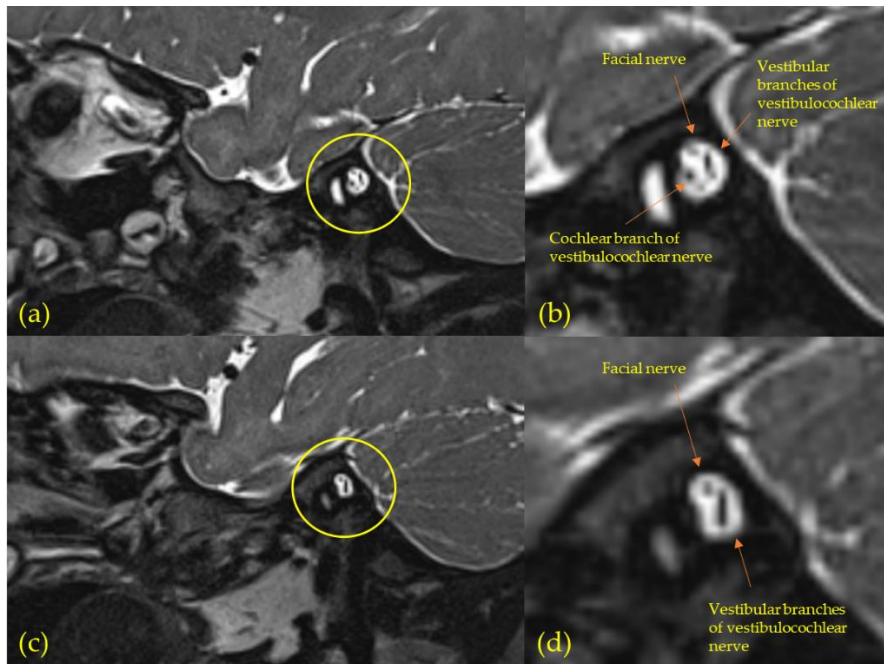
Magnetic resonance imaging (MRI) of the most common malformation in congenital unilateral sensorineural hearing loss (uSNHL), cochlear nerve aplasia or hypoplasia (oblique-sagittal view); (a,b) The normal-hearing ear (NE) of subject 11 (S11) is showing a typical cochlear branch of the vestibulocochlear nerve; (c,d) The impaired ear (IE) of S11 is showing no visible cochlear nerve branch, indicating aplasia or severe hypoplasia. Figure by Johansson et al. (2022) published open access by MDPI.
